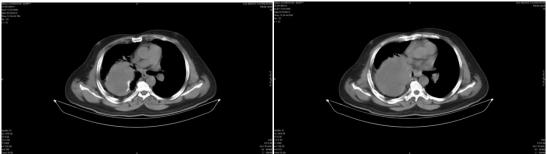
CT Chest showing a mass in the right middle lobe
